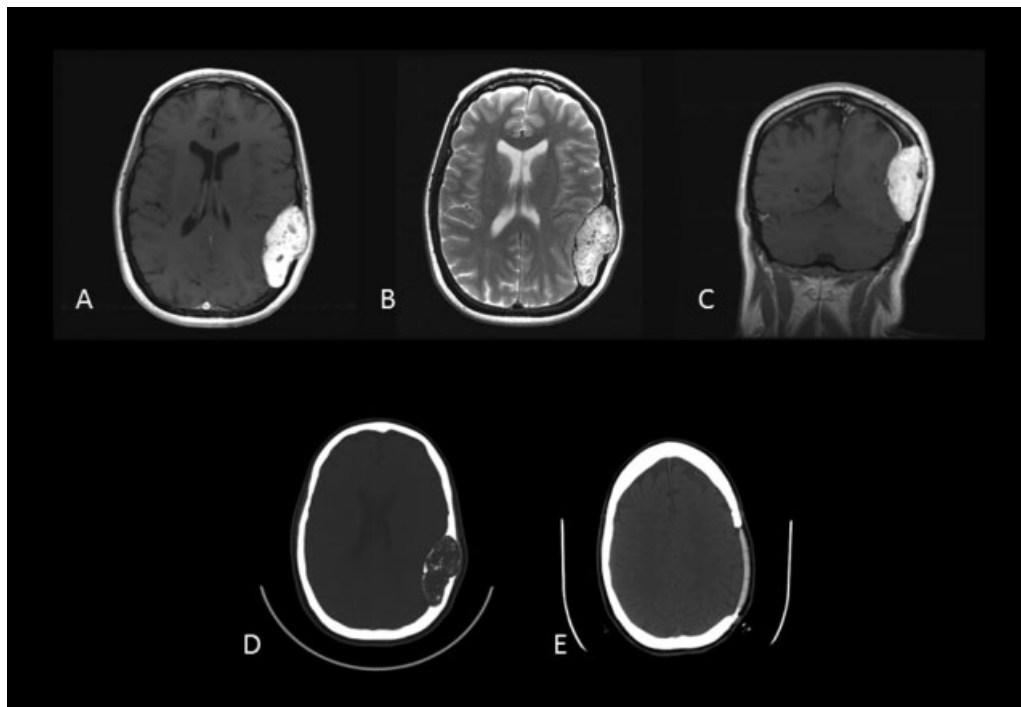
Case 2. Preoperative axial postcontrast T1-weighted MRI (A), axial T2-weighted MRI (B), and coronal postcontrast T1-weighted MRI reveal a large tumor of the parietal bone with its epicenter in the diploe of the skull. The typical pattern of inhomogeneous enhancement on T1-weighted imaging and hyperintensity on T2-weighted imaging is again seen. Preoperative (D) and postoperative (E) axial CT scans reveal complete tumor removal with custom cranial implant replacing the removed bone.
